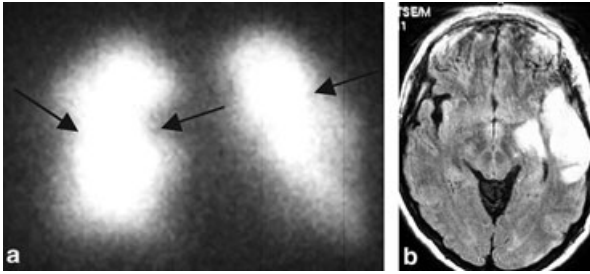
(a) Perfusion pulmonary scintigraphy showing multiple subsegmentary perfusion defects in both lungs, suggesting a multiple pulmonary thromboembolism. (b) Cranial MRI weighted in T2 FLAIR showing an ischemic infarct involving the left MCA territory.
